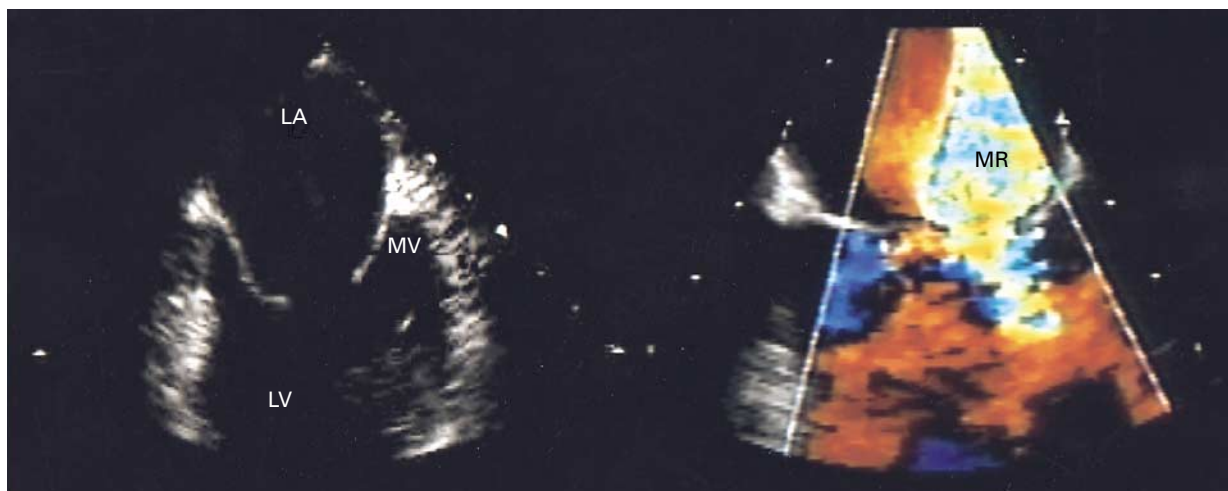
Intraoperative Transesophageal Echocardiograms in Patient 1.
